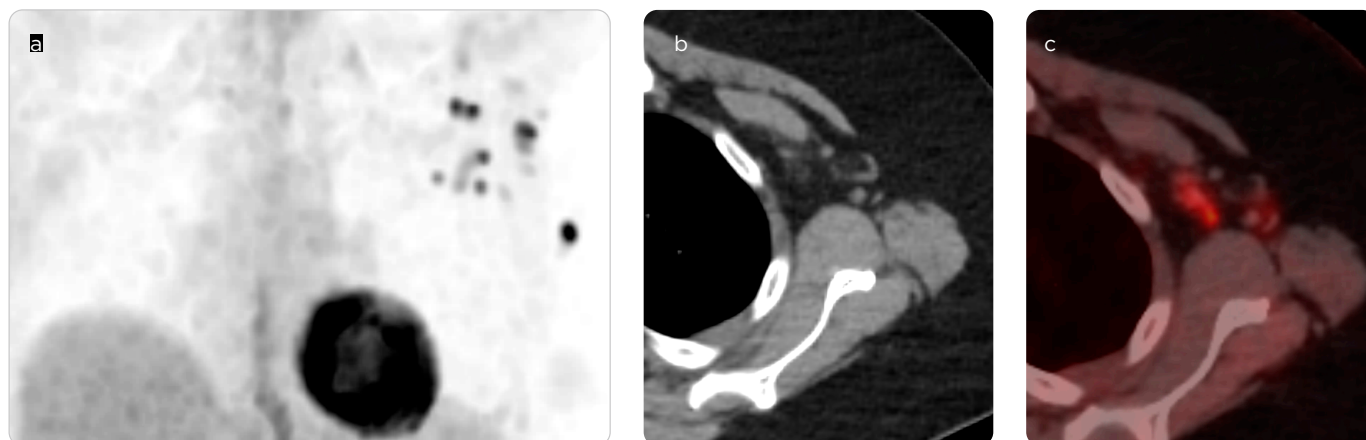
18F-FDG-PET/CT. a) coronal maximum intensity projection (MIP), b) axial CT of the axillary region and c) axial PET/CT fusion. Increased FDG uptake in the axillary nodes, which have an oval shape with central fatty hilum, with a reactive appearance.
